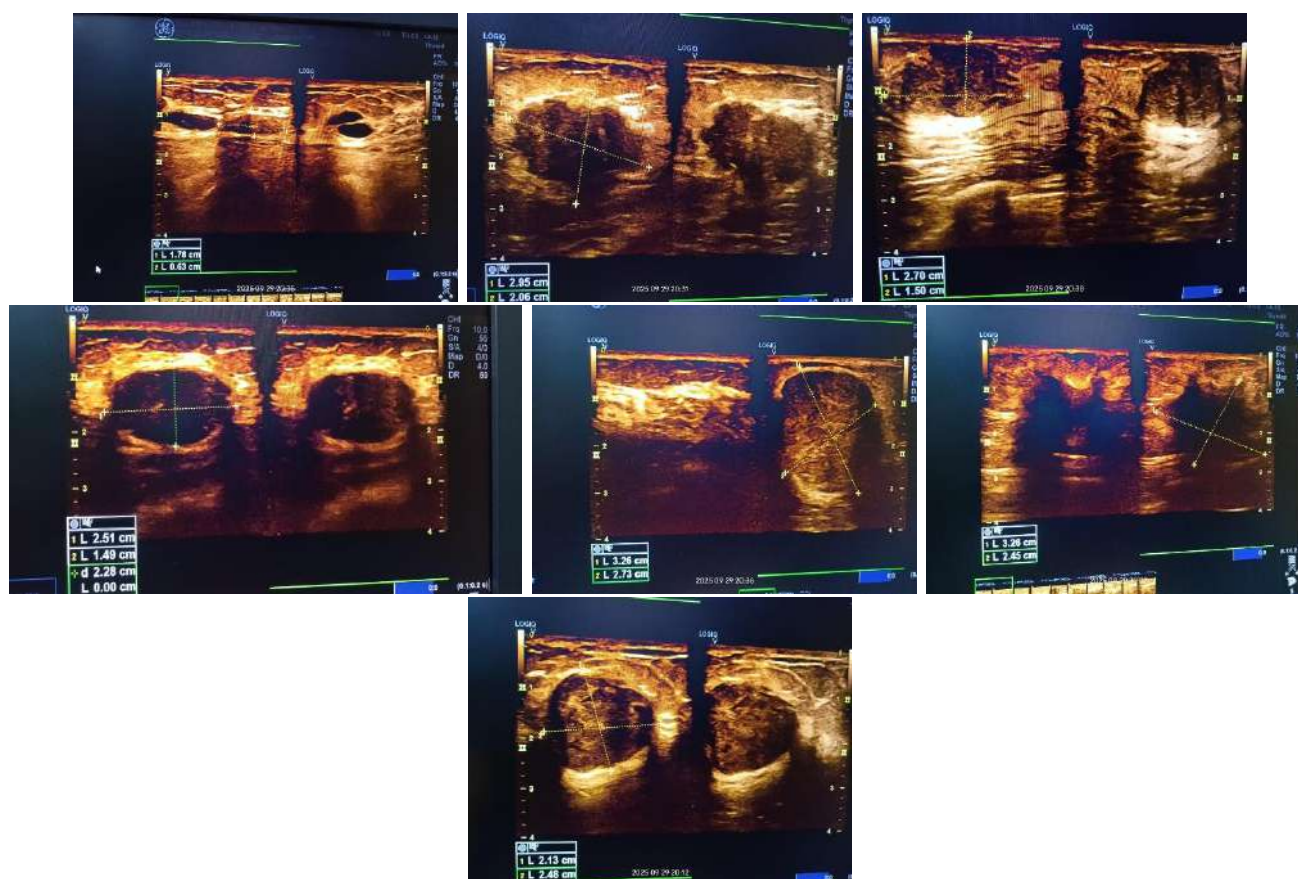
Ultrasonographic appearances of breast masses in the study population
